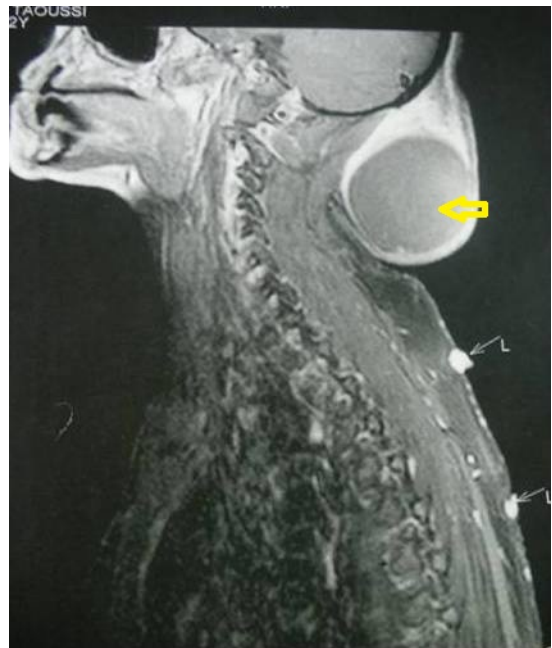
MRI image showing a craniocervical swelling hyperintense on T2.
